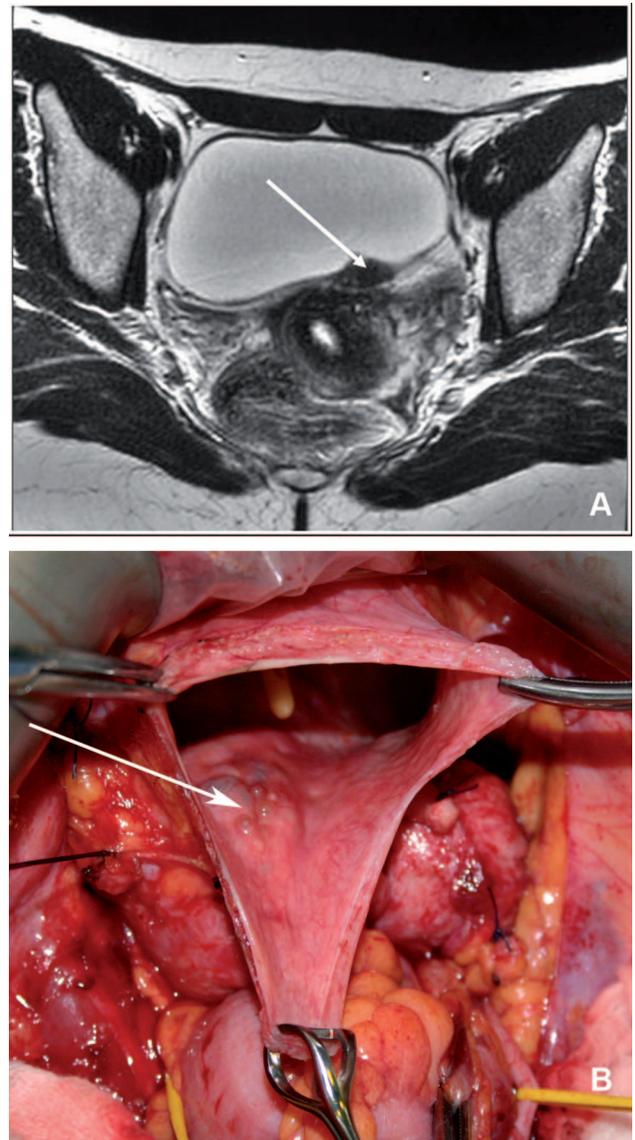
A, MRI axial T2-weighted sequence showing a hypointense nodule infiltrating the posterior bladder wall (white arrow) and (B) surgical view of dark blue endometriotic nodules (white arrow) in the bladder wall after cystostomy prior to partial cystectomy.
